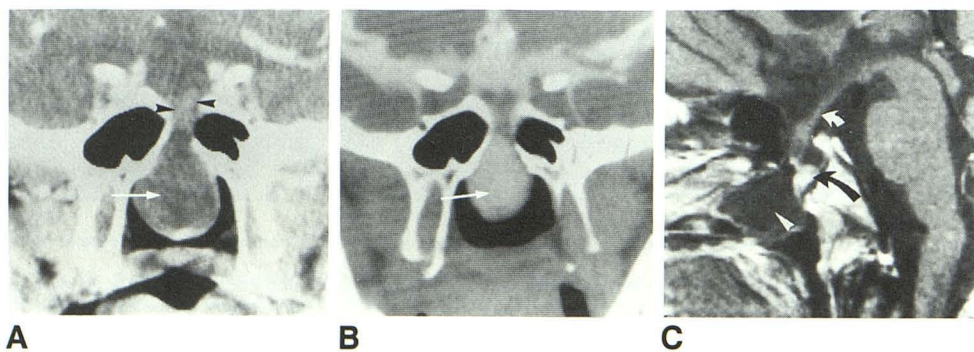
A, Coronal CT section of sella turcica shows liquid nature of mass in rhinopharynx (meningocele) (arrow) and invagination of optic nerves (arrowheads) into bony defect.
